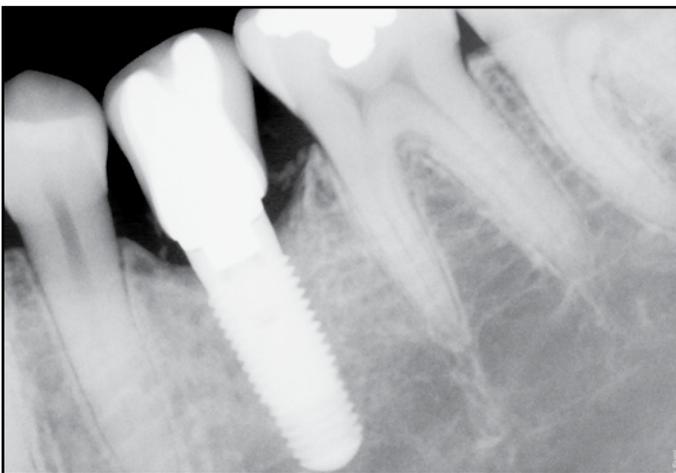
Post-surgical radiograph of implant #20 at 24 months after treatment.
